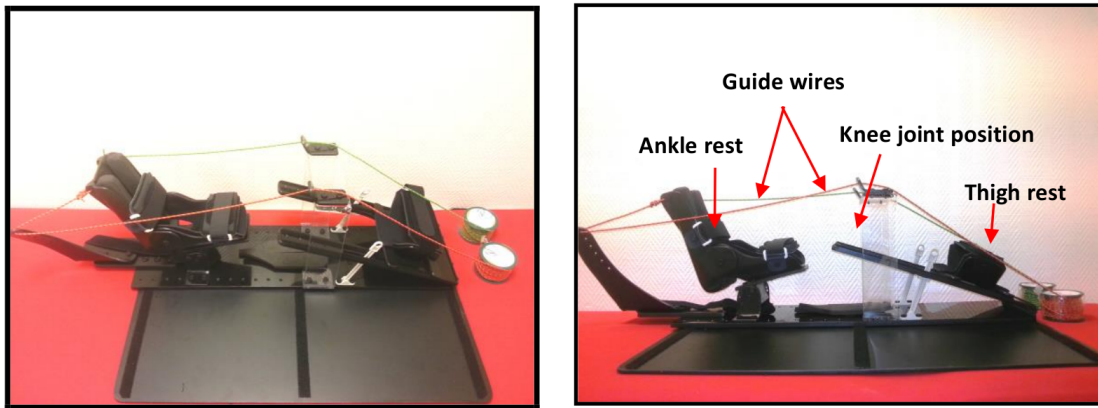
Orthotic fixture specially designed to acquire MRI data on pediatric ankle joint. The entire fixture is made out of MRI-compatible material. Guide wires helped the technician to control and operate the passive plantar-dorsi flexion movements of the ankle joint while rest of the limb is fixed using straps at foot, tibia and mid thigh locations. Position of the ankle rest can be adjusted based on the limb length. Knee angle can be adjusted from full extension to 45° flexion. Cushioned ankle rest supports the foot to be imaged.
